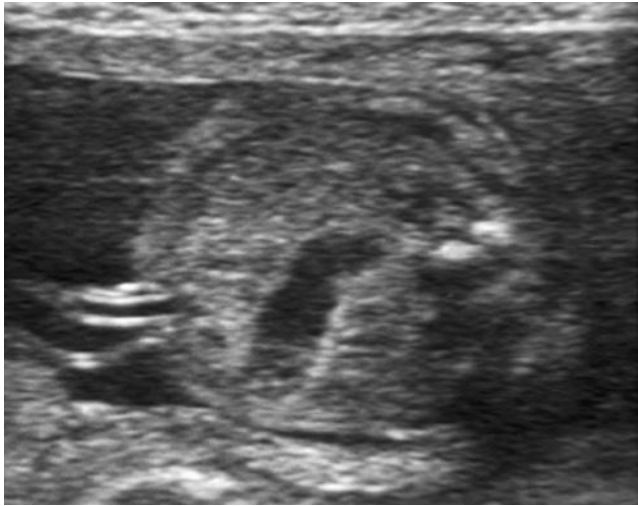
VACTERL association. Sonogram of a fetus with anal atresia and a dilated segment of large intestine. VACTERL, vertebral anomalies, anal atresia, cardiac anomalies, tracheoesophageal fistula or esophageal atresia, renal/urinary anomalies, and limb defect.
